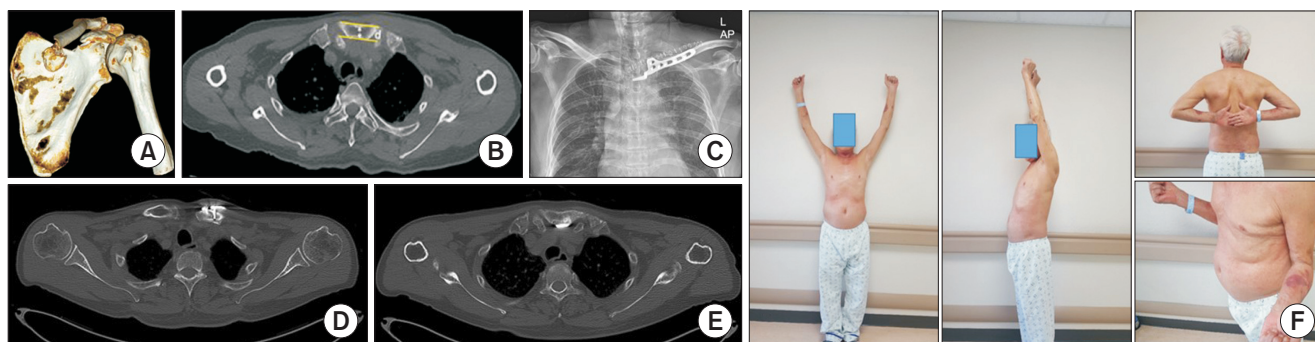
(A) Three-dimensional computed tomography (3D-CT) image of a 68-year-old man who presented with a medial-end fracture of the left clavicle. (B) A hook depth of 15 mm was selected based on the anteroposterior length (d) of the sternal manubrium in the last image where the medial clavicle was observed among the axial images of the preoperative CT scan. (C) Fixation was performed using a hook plate with six holes. (D, E) At 6 months postoperative CT follow-up, the union of fracture site was shown. In the hook portion, osteolysis was observed. (F) There was no pain and full range of motion was observed 6 months after surgery.
